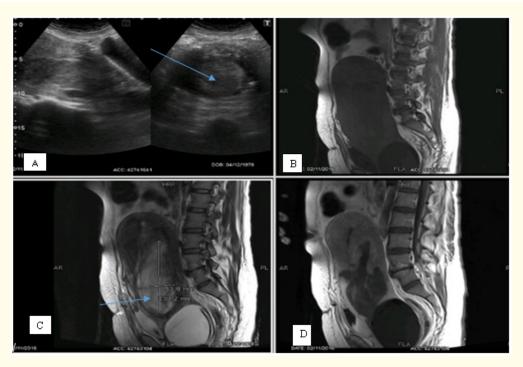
Case One: US (A) shows bulky uterus in keeping with postpartum status. Posterior wall fibroid is extending into upper vagina (arrow). MRI (B, C, D) shows postpartum bulky uterus with tamponade balloon and packing identified within the vagina. Abnormal signal intensity soft tissue lesion arising from posterior wall of the uterus and hanging into the endometrial cavity and upper vagina(arrow). The signals of this soft tissue are suggestive of acute hemorrhage and necrosis within it. The appearances represent a large degenerating sub mucosal prolapsed fibroid arising from posterior wall of the uterus.
